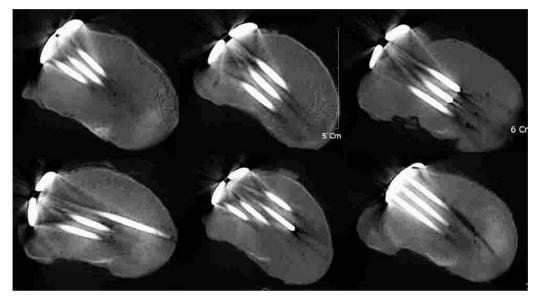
Axial CT images showing bear area of rafting at the posterolateral aspect of the lateral tibial condyle
